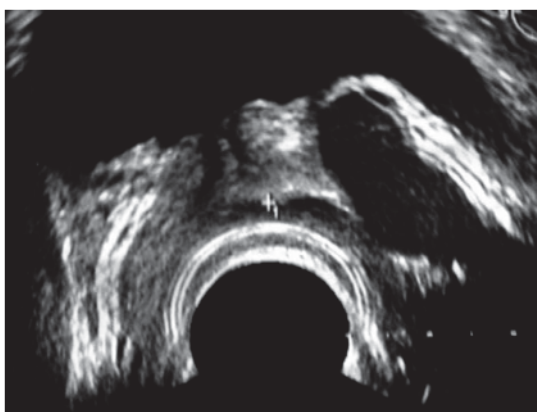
Transrectal ultrasound (TRUS) showing the anechoic tubular structure in the left lobe of the prostate with a proximal extraprostatic extension and a caudal intraprostatic blind end.
